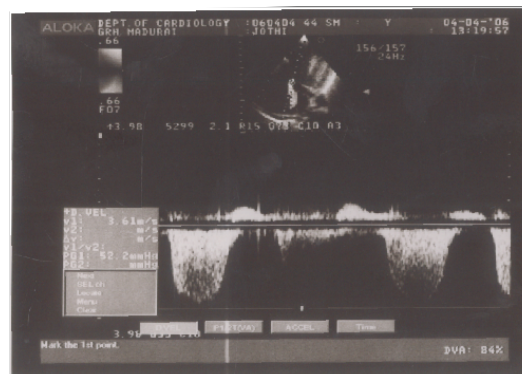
Doppler Echo showing mitral regurgitation
